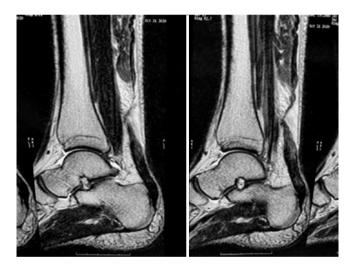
Magnetic resonance imaging (sagittal section) where a complete Achilles tendon rupture in its medial area is visualized.
